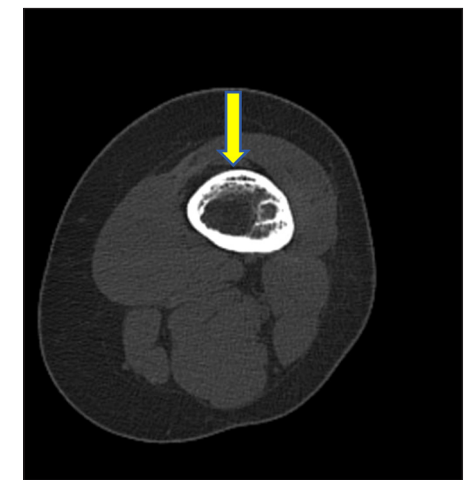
Axial CT image of the left femoral diaphysis, showing a sharply demarcated, round lesion, with a sclerotic border and thickened cortical bone. No cortical breakthrough or periosteal reaction is observed, consistent with a benign, residual, post-surgical lesion.
